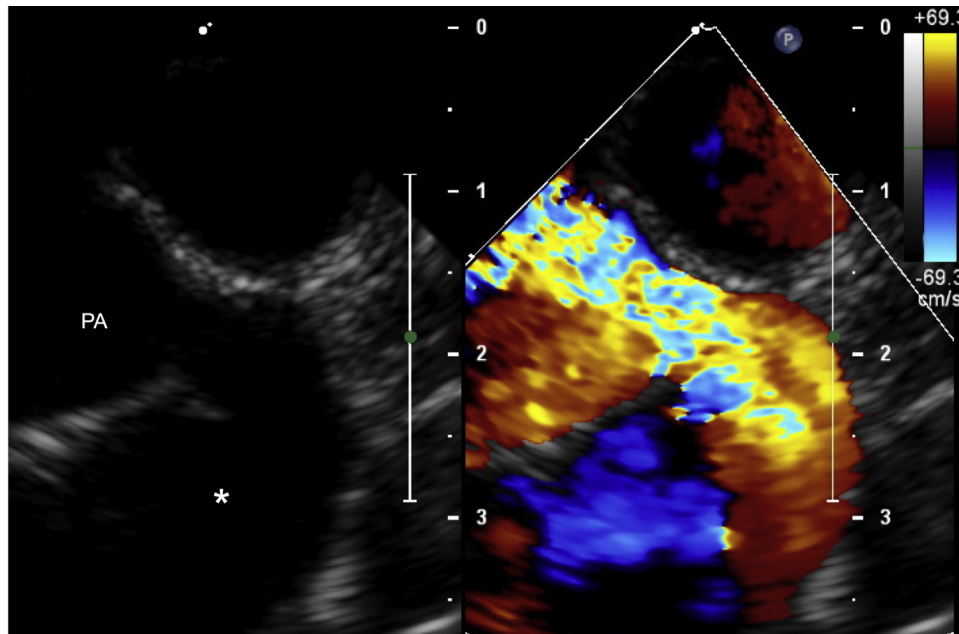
Transesophageal two-dimensional echocardiographic image with color Doppler comparison. The continuously shunting anomalous vessel (*asterisk*) is seen inserting into the ventral aspect of the pulmonary artery (PA).
